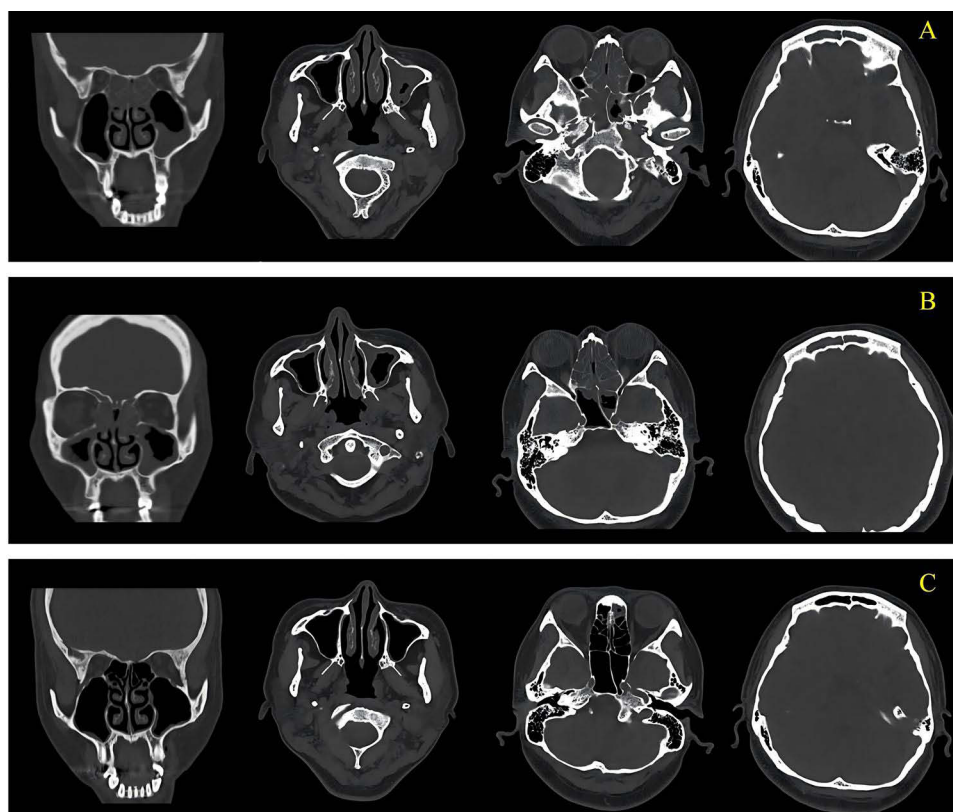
Imaging data of the case. CT before conventional medication (A), three months after conventional medication (B), and six months after dupilumab (C).
